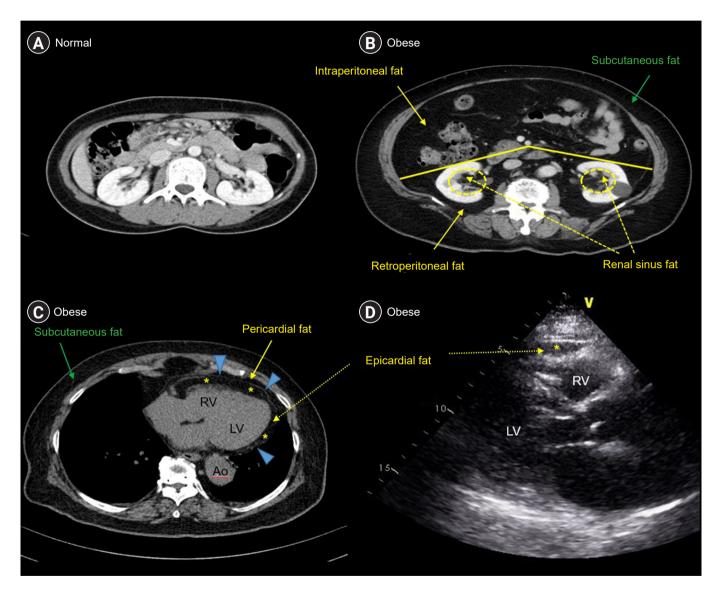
Examples of subcutaneous and visceral fats. Panels A and B are representative abdominal computed tomography (CT) images of normal-weight (A) and obese (B) individuals. Panels C and D show representative cardiac images of obese individuals (C, chest CT; D, echocardiography). Green and yellow colors denote subcutaneous and visceral fats, respectively. Yellow asterisks indicate epicardial fat.
